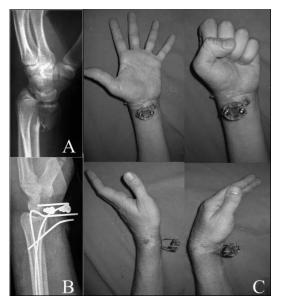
A) Pre-operative x-ray of a volar displaced distal radius fracture; B) Post-operative x-ray after treatment with the Epibloc elastic-dynamic fixation; C) Post-operative active wrist motion at seven days follow-up (Rocchi L, 2017)
